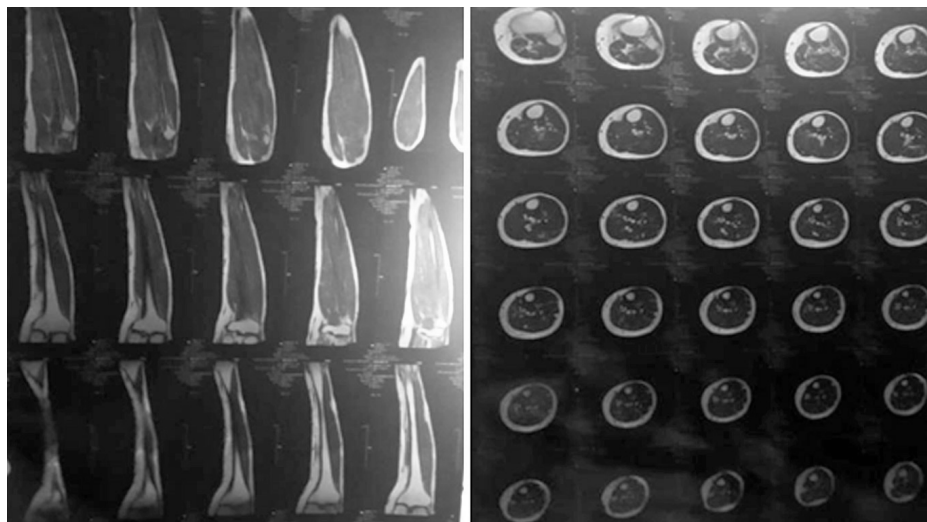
Plane MRI Findings of Left lower Leg, Axial and Coronal images.
